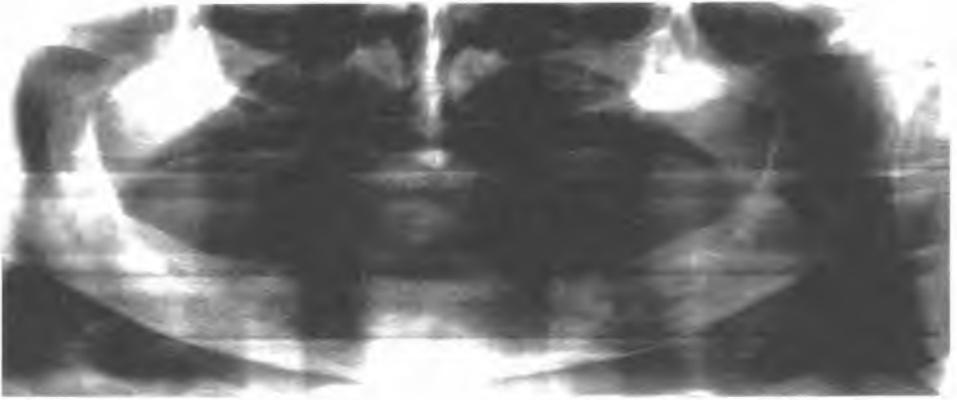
Panoramic X-ray in case of mandibular neoplasm shows a bone defect in the region of left angle and body of the mandible
